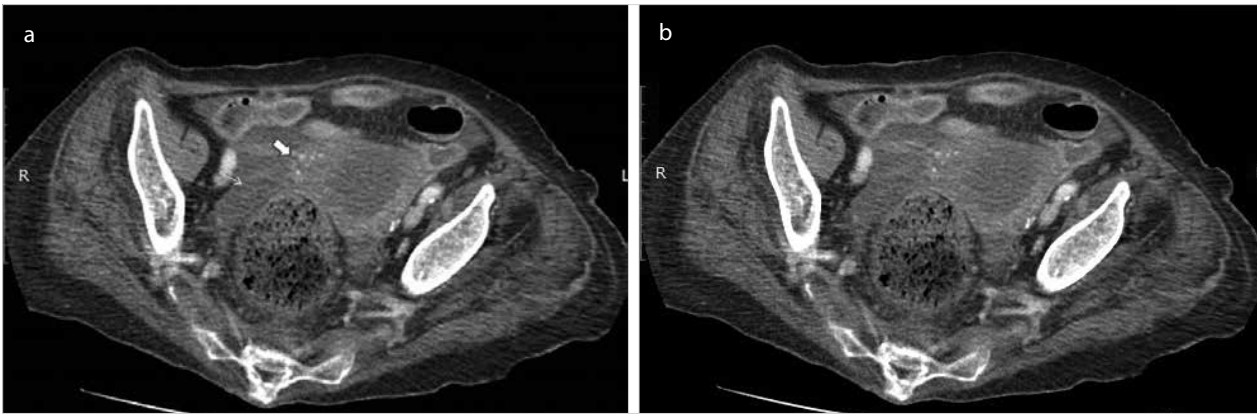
a, b. Axial (solid arrow) (a) and arrow (b) show contrast-enhanced CT images obtained through the midportion of the uterus showing a distended endometrial cavity with perforation at the fundus in the right side (solid arrow), presence of collected fluid within the pelvic cavity (arrow)
